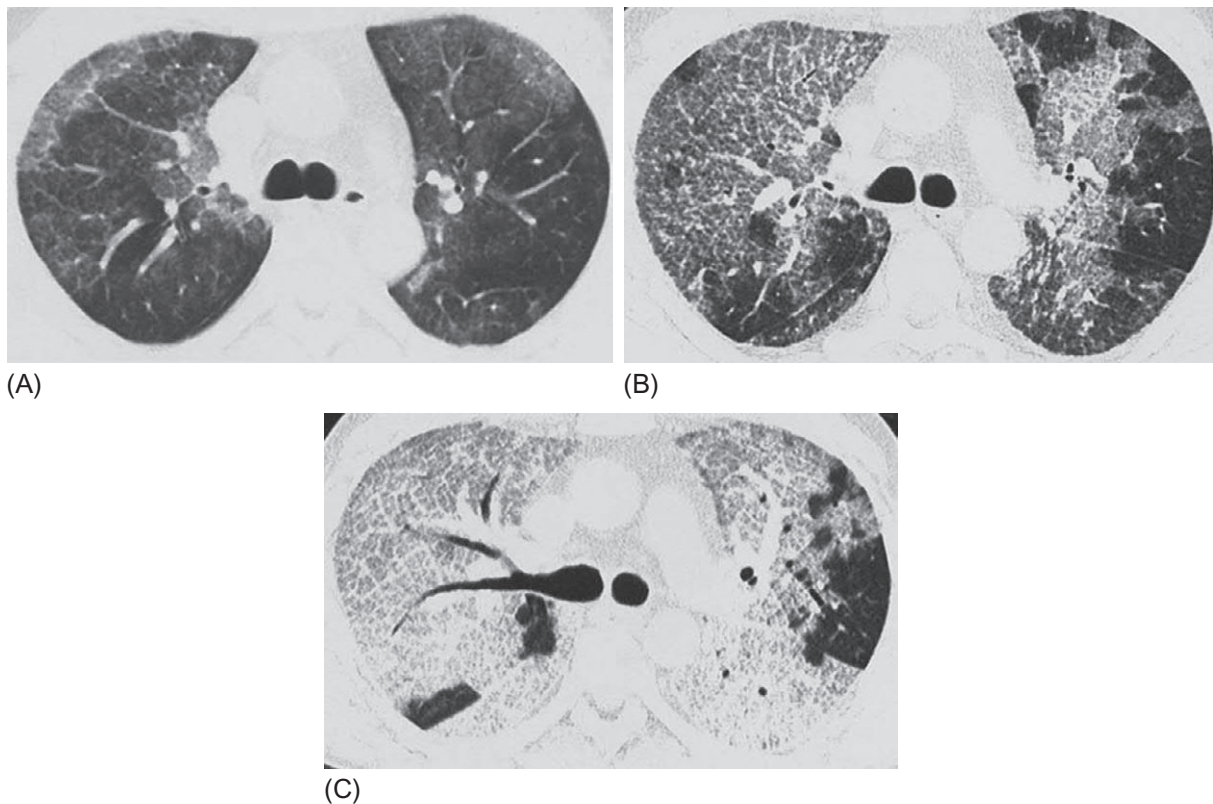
HRCT monitoring of the effectiveness of therapeutic BAL before (A) and 5 days after (B) the procedure in a 37-year-old patient. A mild decrease lung attenuation in the ground-glass areas.
